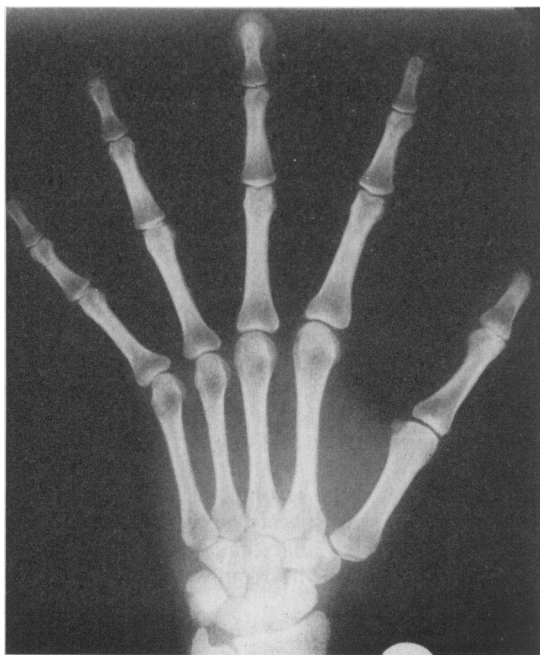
Radiograph of hand showing arachnodactyly.
